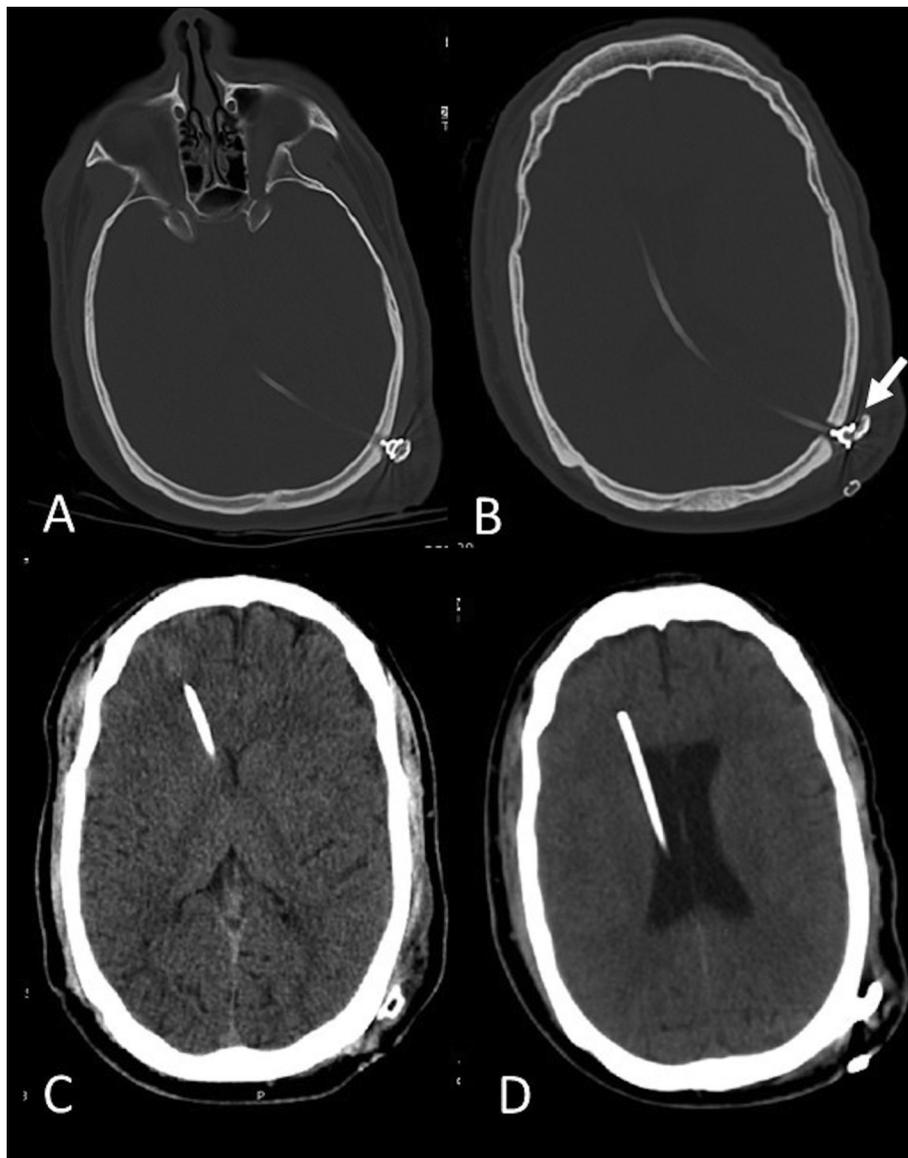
Brain CT scans demonstrating the position of the shunt on the night of the accident (A) and 2 days later (B). Arrow indicates the displacement of the extracranial portion of the shunt. Brain CT scans are also used to evaluate for hydrocephalus, with none demonstrated on the day of the accident (C), and enlarged ventricles exhibited 2 days later (D).
